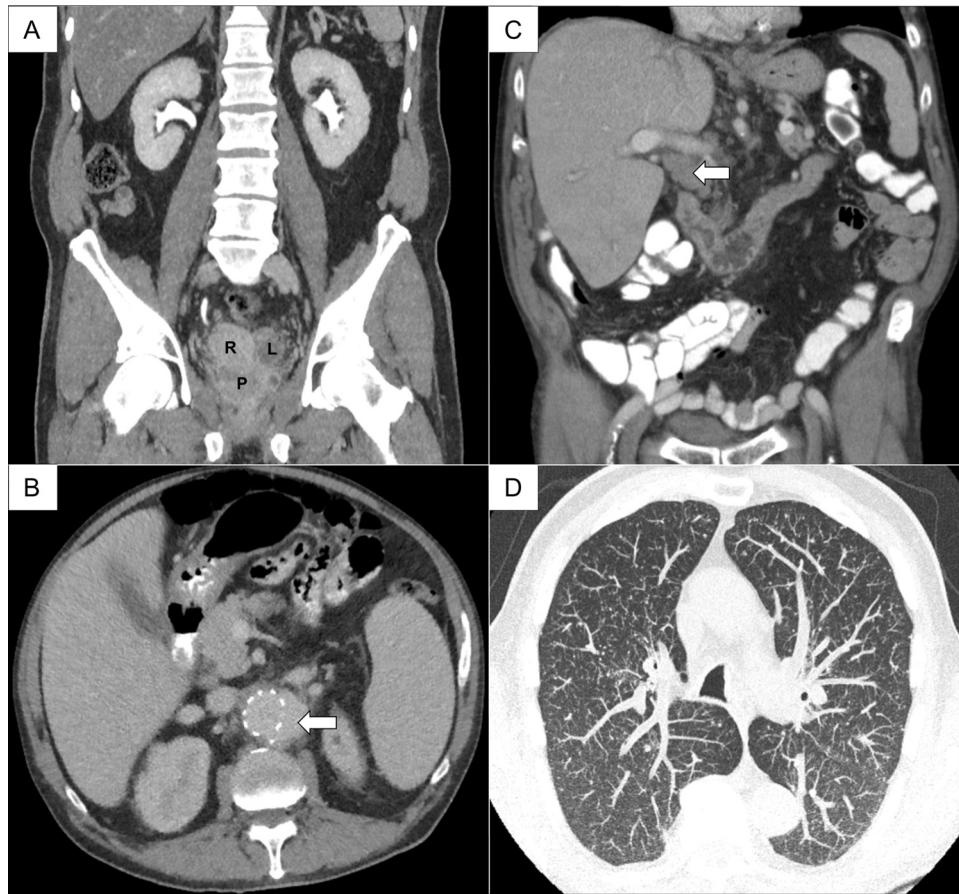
(A) Pelvic CT scan (coronal plane) of patient 1, displaying an inhomogeneous, enlarged prostate (P) and asymmetry of the seminal vesicles with hyperdensity of the right seminal vesicle (R) compared to the left seminal vesicle (L). (B) Transverse abdominal CT scan of patient 2 showing leakage of contrast fluid (arrow) outside the endovascular aortic stent. (C) Abdominal CT scan (coronal plane) of patient 4 showing hepatomegaly (craniocaudal diameter 22 cm) and perihilar lymphadenopathy (white arrow). (D) High-resolution thoracic CT scan (maximum intensity projection) of patient 4 demonstrating a bilateral miliary pattern with multiple sub-millimetre pulmonary nodules.
